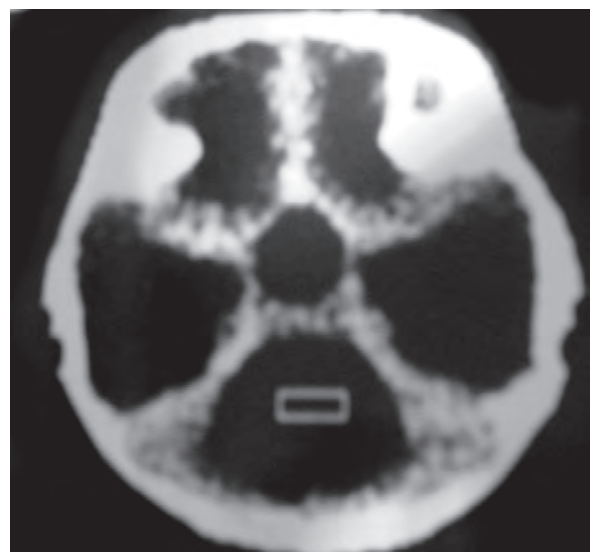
CT scan of the brain showing Dandy Walker malformation
